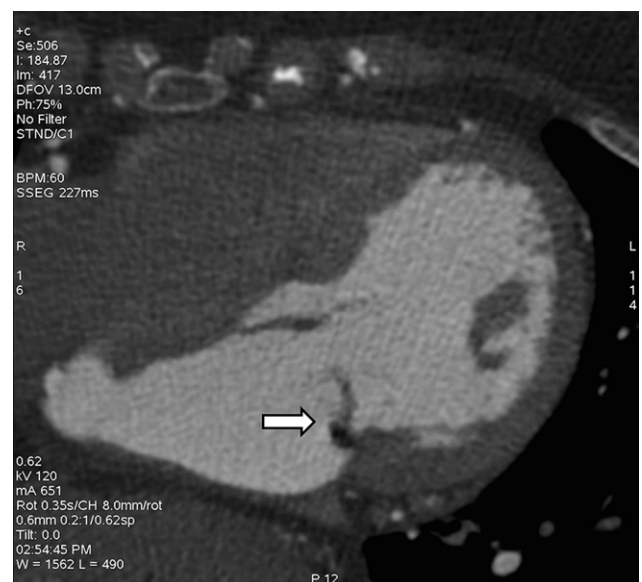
Multidetector computed tomography axial 4-chamber angiography shows a flail posterior mitral valve leaflet (*arrow*), causing severe mitral regurgitation.
